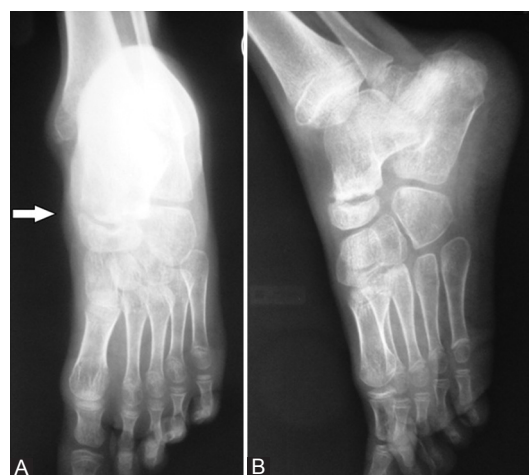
Post-treatment radiographs (AP and oblique) showing remineralization of bones with sclerosis of joint margins and reformation of the joint space of the talonavicular joint and disappearance of soft tissue.
